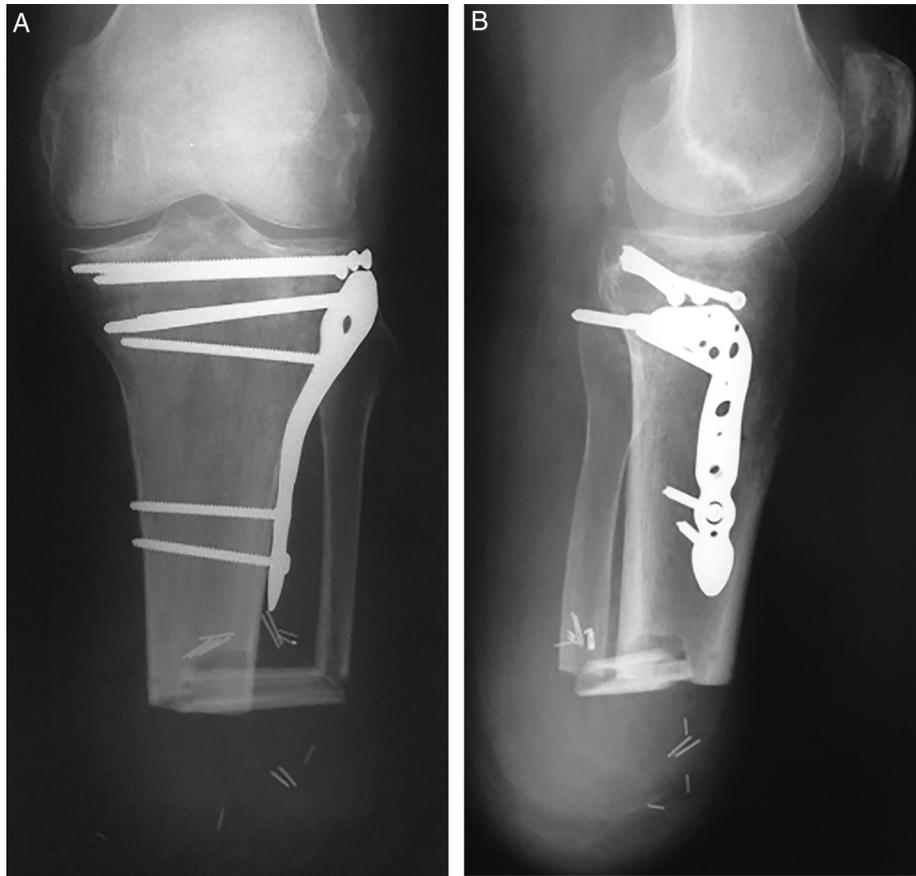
Postoperative (A) anteroposterior and (B) lateral radiographs of the left knee demonstrating the residual limb status after below the knee amputation using an Ertl procedure.
